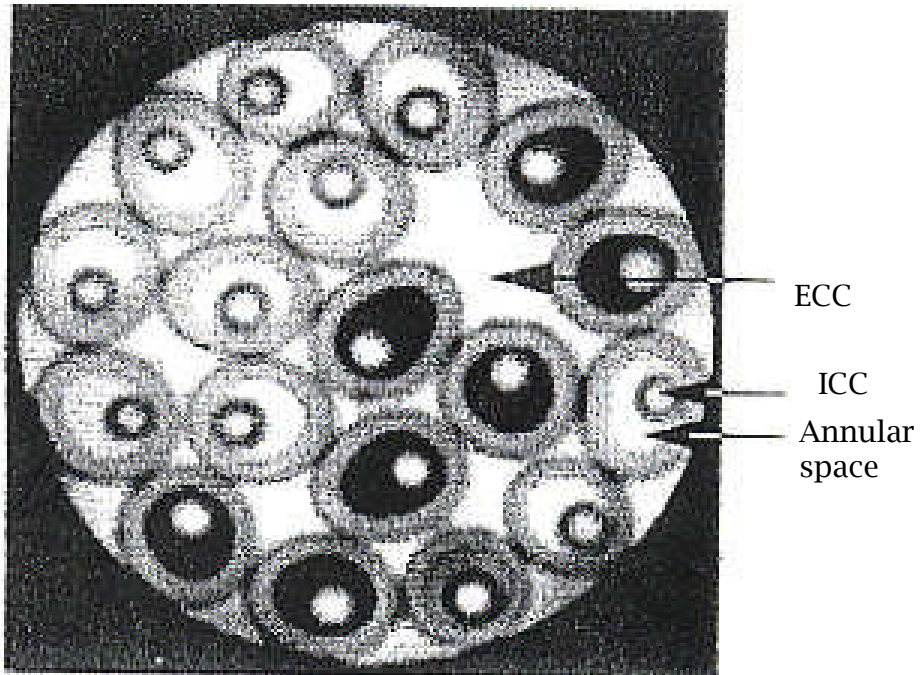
MRI picture of the arrangement of the fibers of Macdonald et al design. ECC, Extra-cellular compartment; ICC, Intra-cellular compartment [15].
